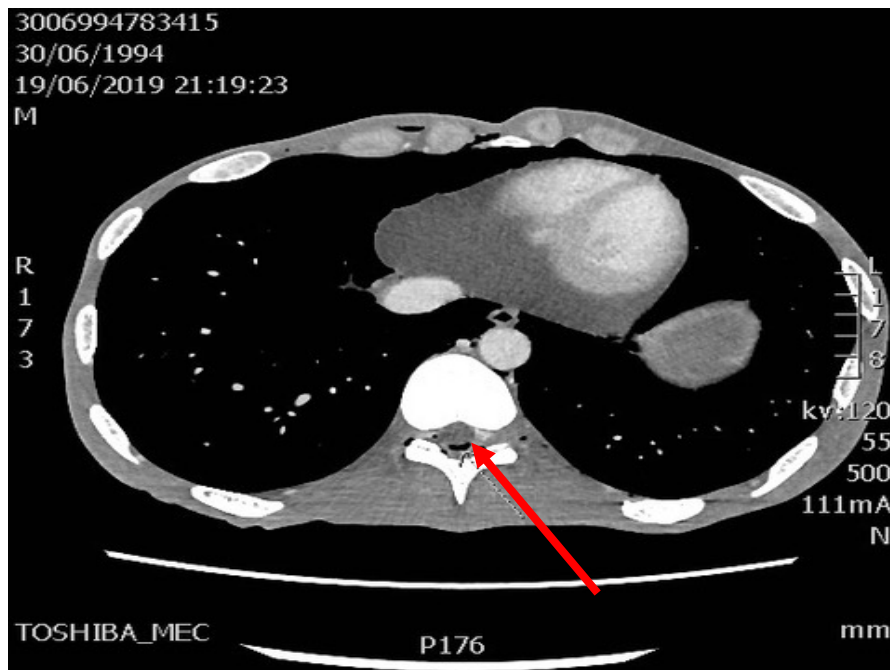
Computed tomography scan shows air in the spinal canal (red arrow indicates change).
